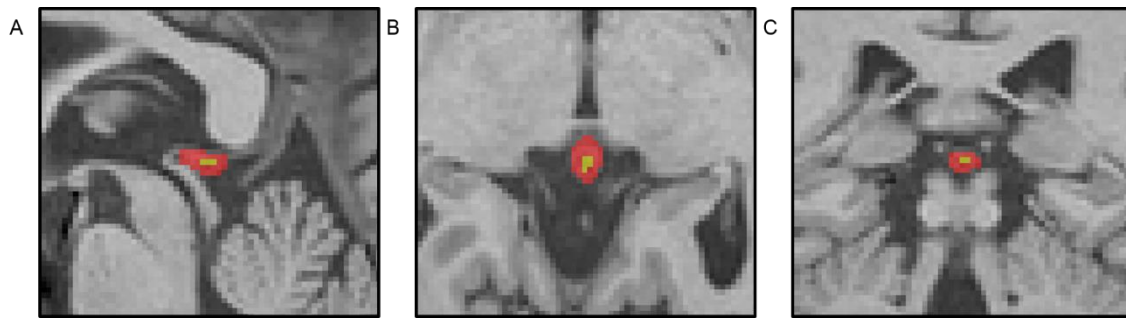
Segmentation of pineal gland volume on 3D T1-weighted brain magnetic resonance imaging. Sagittal (A), axial (B), and coronal (C) views of sample brain MRI of the pineal gland in subjects with pineal cysts (71 years old, men, normal cognition). The pineal gland (colored in red) and pineal cysts (colored in yellow) were identified, and then the pineal parenchyma was defined.
